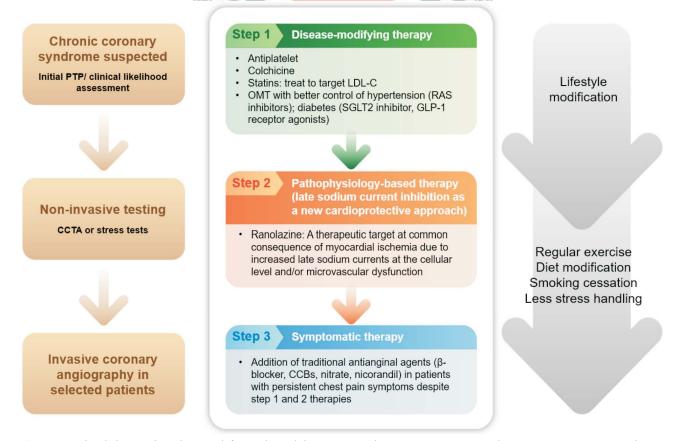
Tailored pharmacological approach for CCS beyond the angina paradigm. CAD, coronary artery disease; CABG, coronary artery bypass graft surgery; CCBs, calcium channel blockers; CCTA, coronary computed tomography angiography; CCS, chronic coronary syndrome; GLP-1, glucagon-like peptide-1; LDL-C, low-density lipoprotein cholesterol; OMT, optimal medical therapy; PTP, pretest probability; RAS, renin-angiotensin system; SGLT2, sodium-glucose cotransporter 2.
